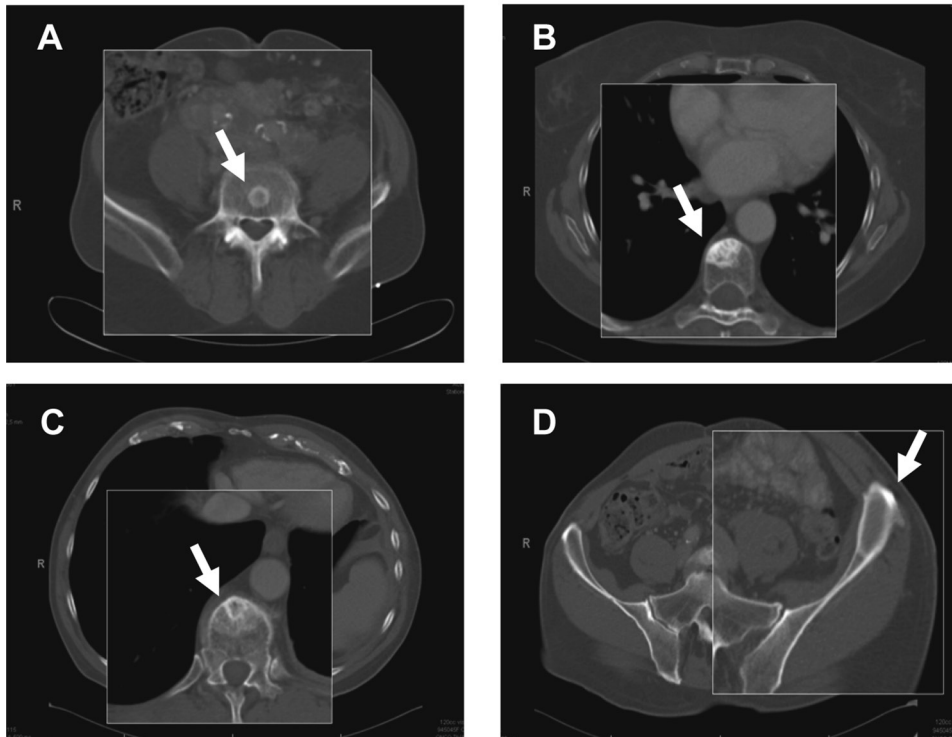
Roentgenologic CT appearance (transversal slices; zoomed in on bone metastases) of gastroenteropancreatic and bronchial NETs. Arrows indicate relevant bone lesion. (A) Small sclerotic rim. (B) Larger sclerotic area. (C) Vague sclerotic area with sclerotic rim inside. (D) Lytic lesion with sclerotic rim.
